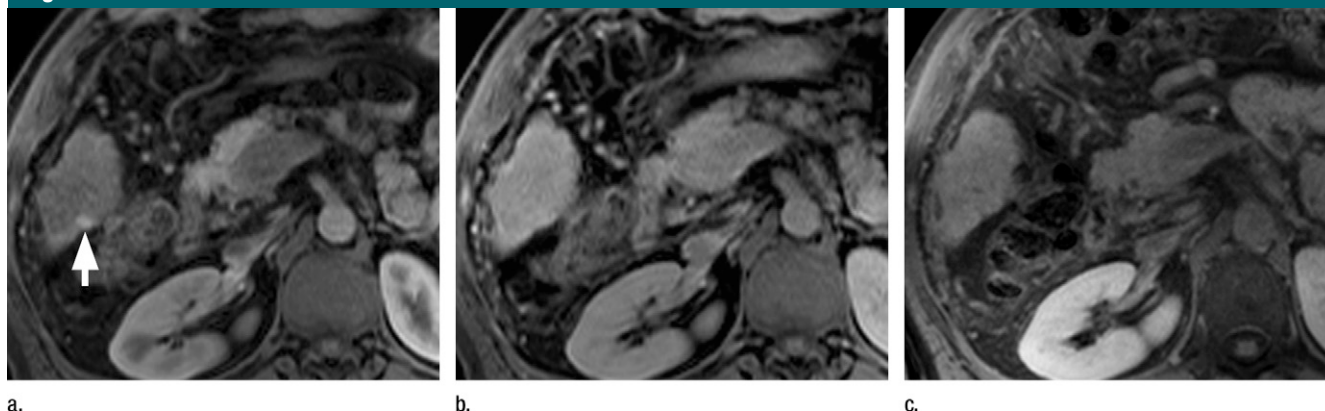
Images in a 45-year-old man with hepatitis C (Child-Pugh class B) and two HCCs (confirmed at transplantation). (a) Transverse T1-weighted three-dimensional spoiled GRE gadoxetate disodium–enhanced MR image obtained with fat saturation and VIBE during the hepatic arterial phase demonstrates a 0.5-cm subcapsular lesion (arrow) with high signal intensity in the right lobe of the liver. (b, c) Corresponding MR images obtained during the (b) delayed and (c) liver-specific hepatobiliary phases. The lesion is isointense to adjacent hepatic parenchyma. Because of the small lesion size, the subcapsular location, and the lack of the washout sign, this lesion was assigned a low score for malignancy (score of 1) by all readers; however, it was confirmed to be HCC at pathologic analysis of the explanted liver.
